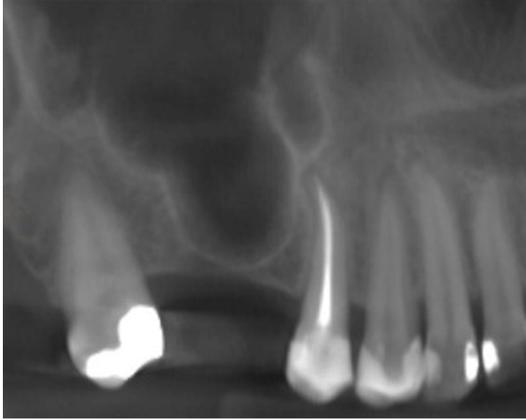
Preoperative Computed Tomography (CT) based panoramic view of the upper right molar site. Note the extended sinus pneumatization.
